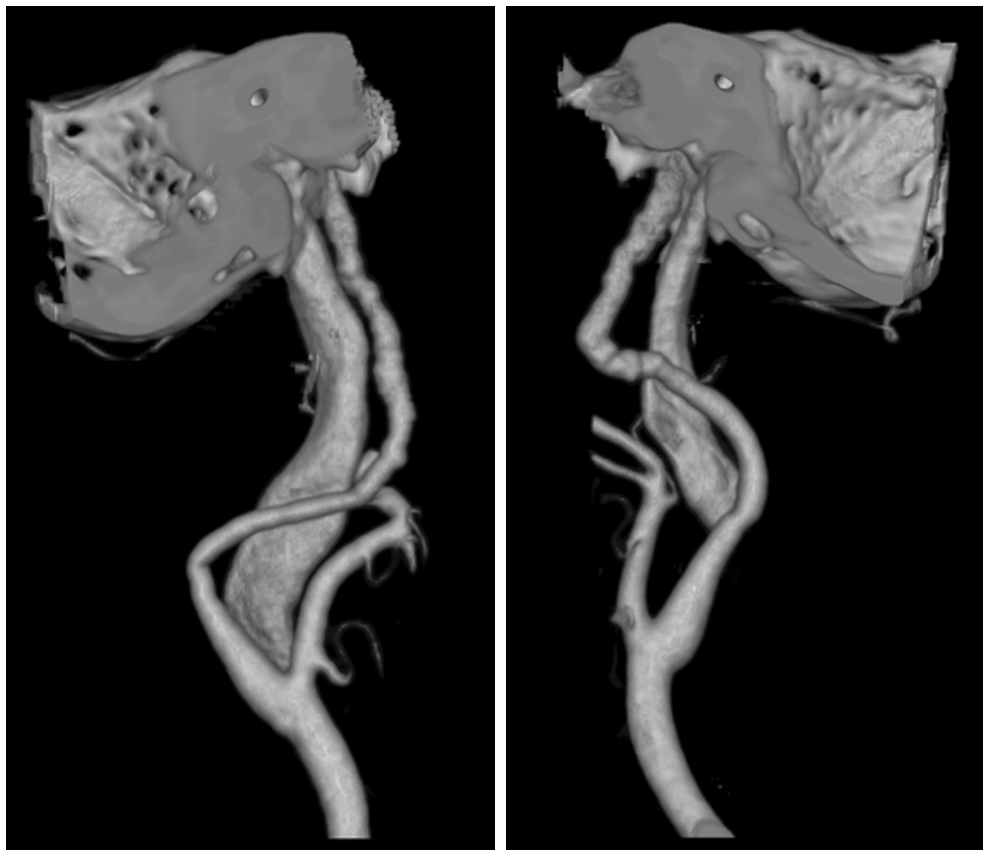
78-year-old woman with left amaurosis fugax. A and B, Volume-rendered CT angiograms of left (A) and right (B) carotid arteries. String-of-beads appearance of internal carotid artery is visible at distal extracranial internal carotid artery on both sides.
